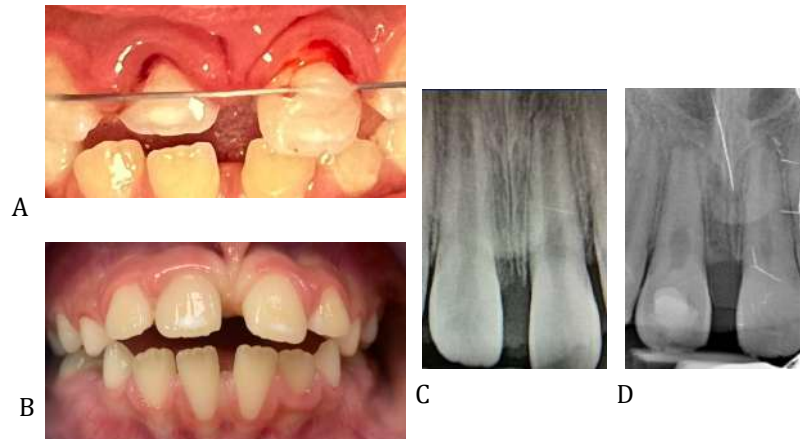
(A, C) Frontal view and occlusal radiograph centered on the maxillary incisors on the day of the trauma. (B) Frontal view nine months after the trauma. (D) Periapical radiography eleven months after the trauma and five months after the revascularization procedure.
